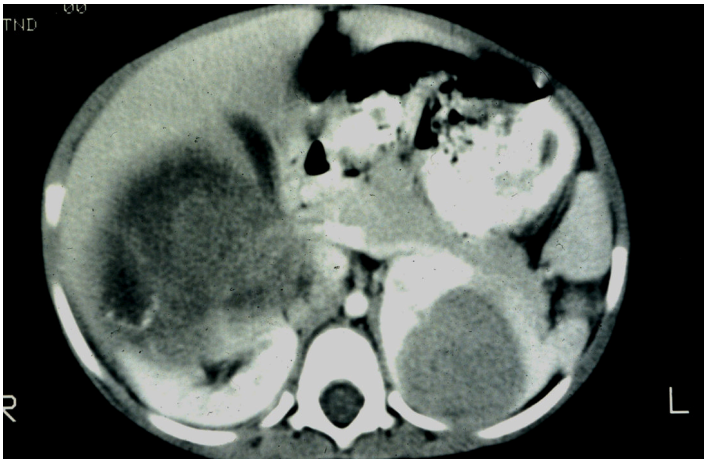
Abdominal computed tomography in a child with bilateral Wilms' tumor. There is a very large right kidney tumor and a smaller but significant left kidney mass. Chemotherapy resulted in tumor shrinkage in both tumors allowing complete resection and survival.
